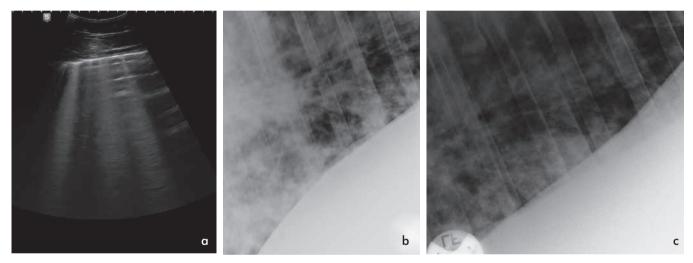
4a: Case 2: Ultrasonographic image of the right side of the thorax at diagnosis of EMPF. Notice the numerous comet tail artefacts. 4b and c: Case 2: Radiography of the chest at day of diagnosis revealed increased density of lung tissue with a nodular and severe interstitial pattern. | 4a: Fall 2: Ultraschallbilder am Tag der EMPF Diagnose Stellung: viele Kometenschweifechos sind sichtbar. 4b und c: Fall 2: Röntgenaufnahmen am Tag der Diagnosestellung. Das Lungengewebe ist verdichtet im Sinne eines nodularen und interstitiellen Musters.
